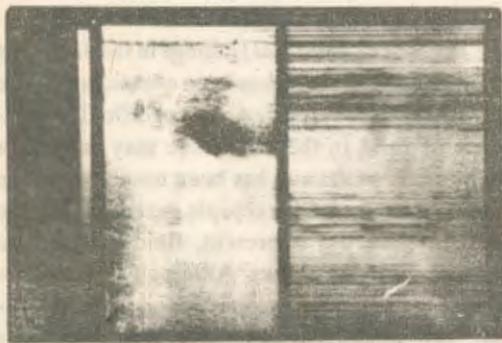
"Ultrasonography showing gestational sac outside uterus with cardiac tracing and fluid in Cul-de-sac".
